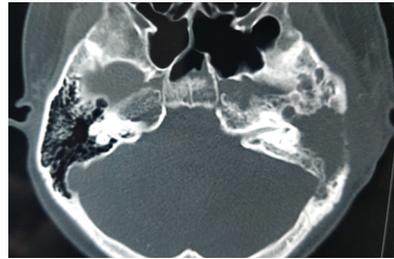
thinning of dural plate and sigmoid plate on HRCT temporal bone
